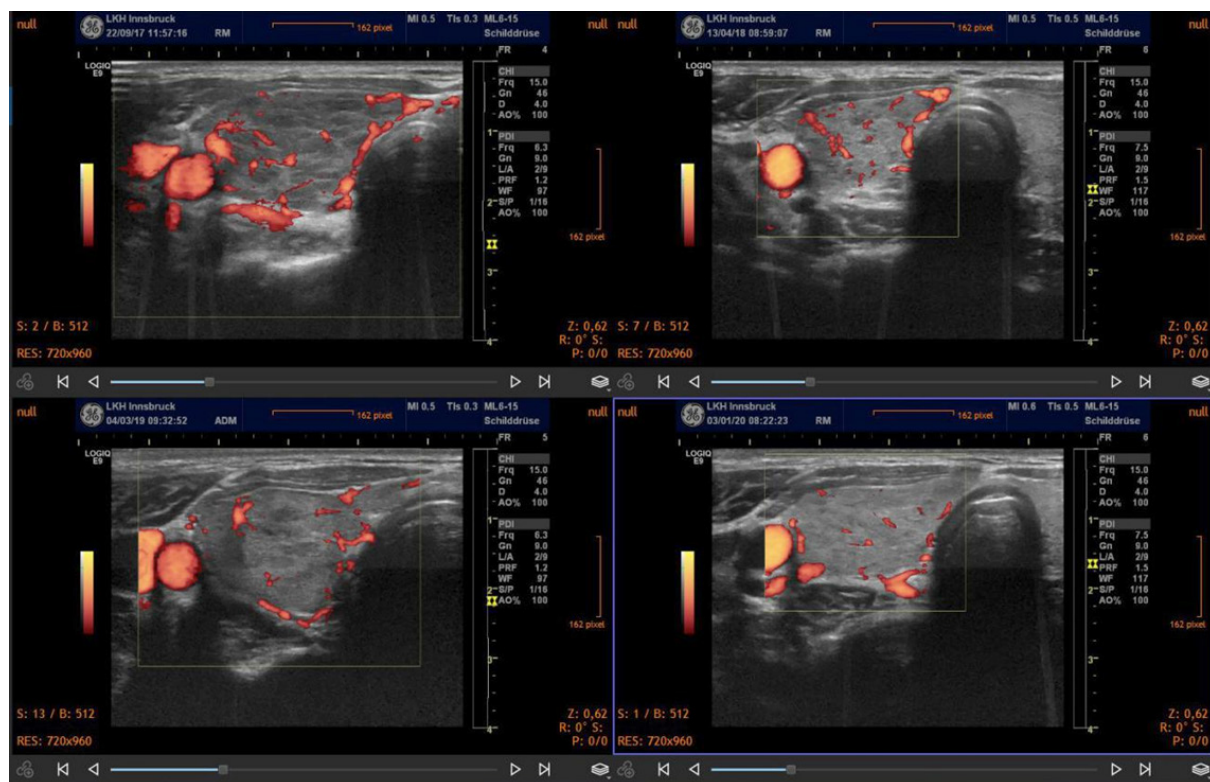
Power Doppler sonography showing a diminution of perfusion September 2017 to January 2020. Thyroid size decreases, morphology improves and perfusion returns to normal
